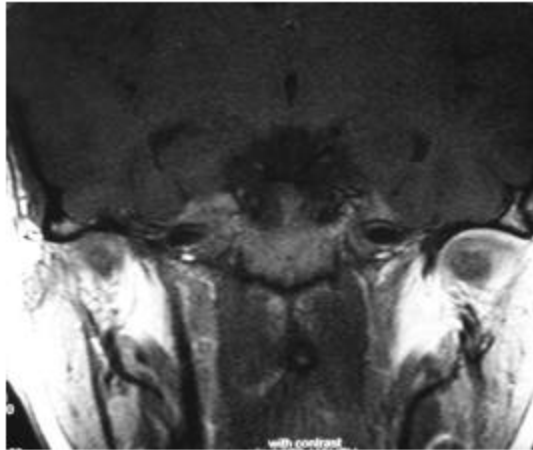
Magnetic resonance imaging T<sub>1</sub> weighted image with contrast. It shows synovial enhancement of both temporomandibular joints more on left side in a patient with juvenile idiopathic arthritis
